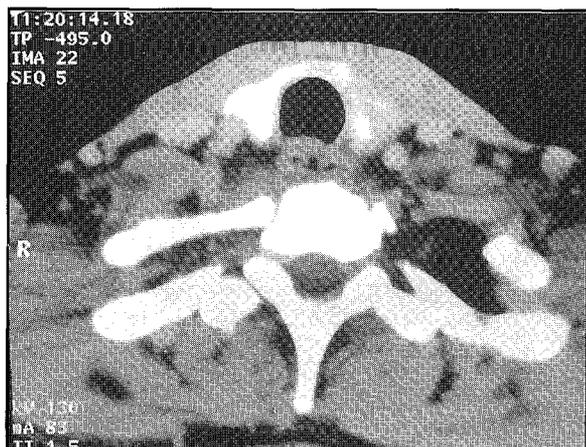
The CT scan of neck after intravenous non-ionic contrast revealed an ill-defined iso to hypodense soft tissue mass in the left lobe of the thyroid
